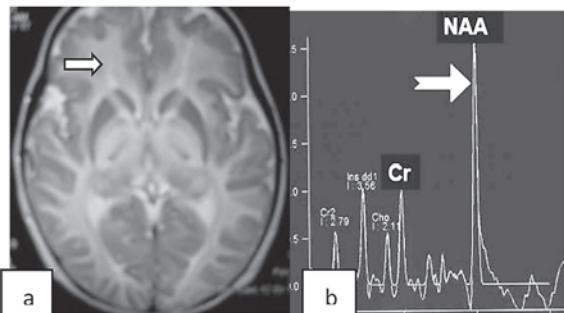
Canavan disease Axial T2 MR image showing periventricular and subcortical white matter including U fibers and bilateral globus pallidi
